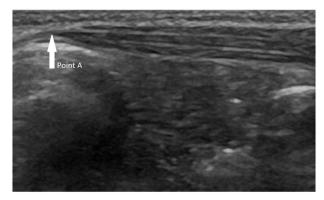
The saved deidentified ultrasound imaging of the abdominal wall musculature. Point A refers to the medial landmark, the medial aspect of the internal oblique muscle.
